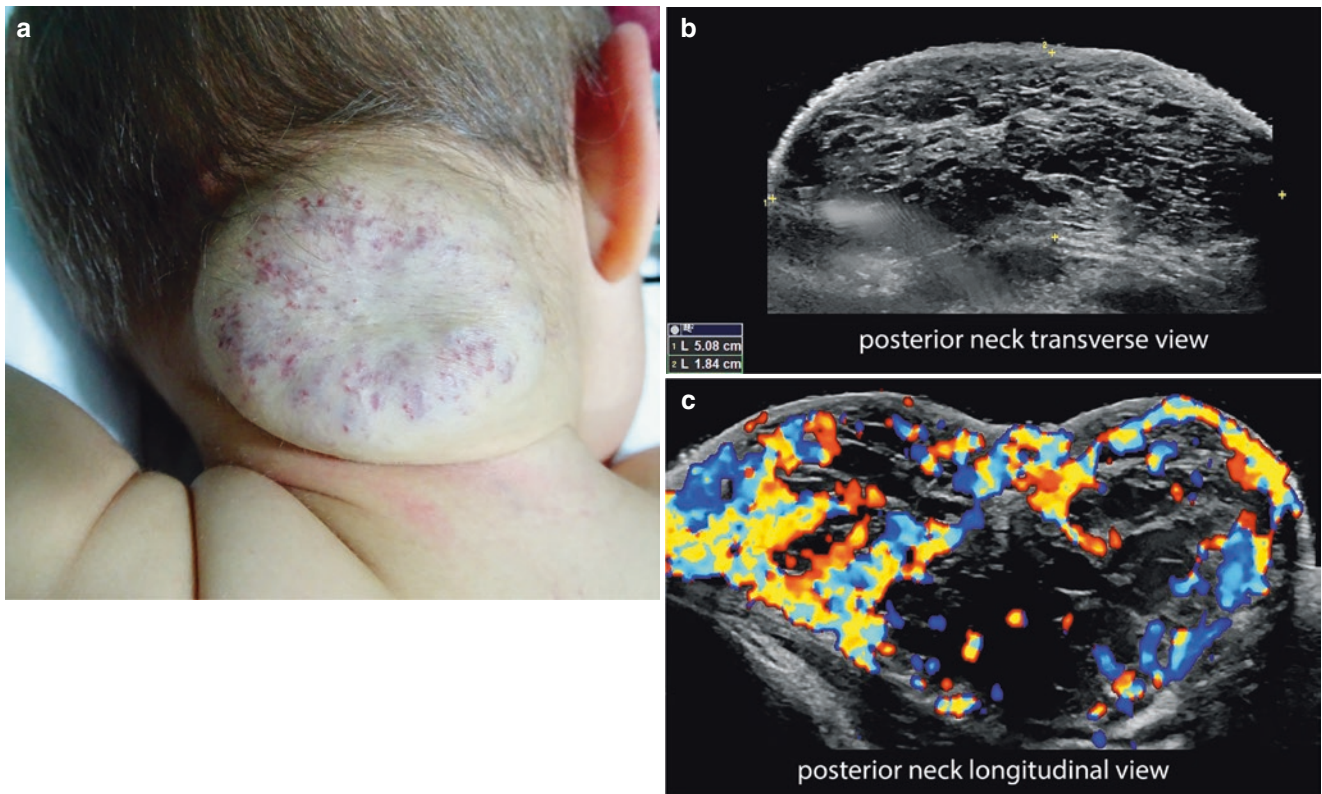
Non-involting congenital hemangioma (NICH). Follow-up at 1 year and 6 months of the same case as in Fig. 4.11. (a) Clinical image (posterior neck). (b and c) Greyscale and color Doppler ultrasound (b, transverse view; c, longitudinal view) show no significant changes in the diameter of the lesion, a 5.0-cm (transverse) \times 1.8-cm
